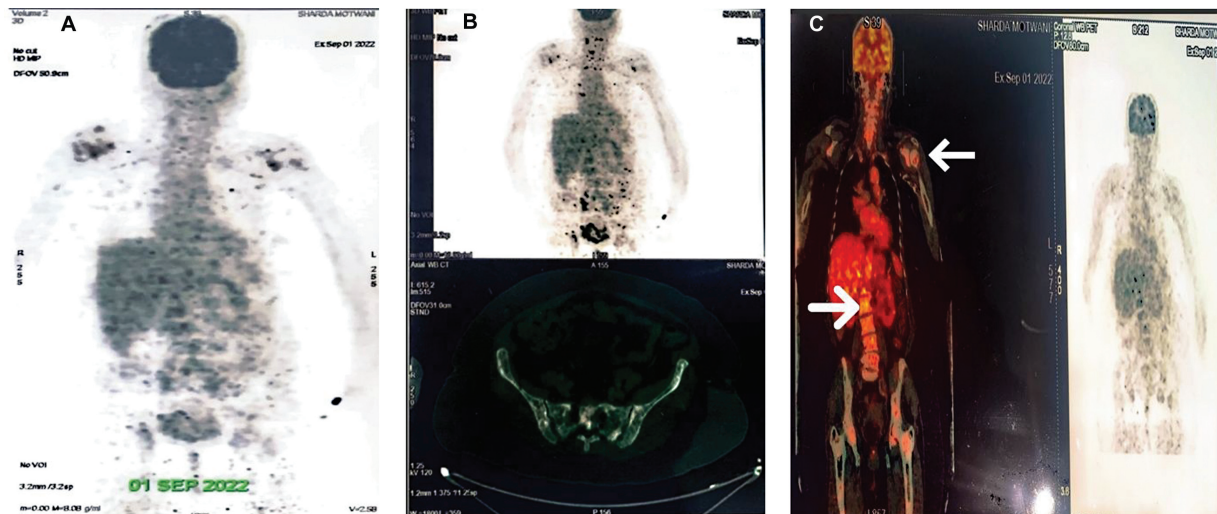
(A–C) Whole-body fluorodeoxyglucose positron emission tomography and computed tomography (FDG-PET/CT) scan shows metabolically active lytic and sclerotic lesions (white arrows) involving almost the entire visualized skeletal system. There was no activity elsewhere in the body.
